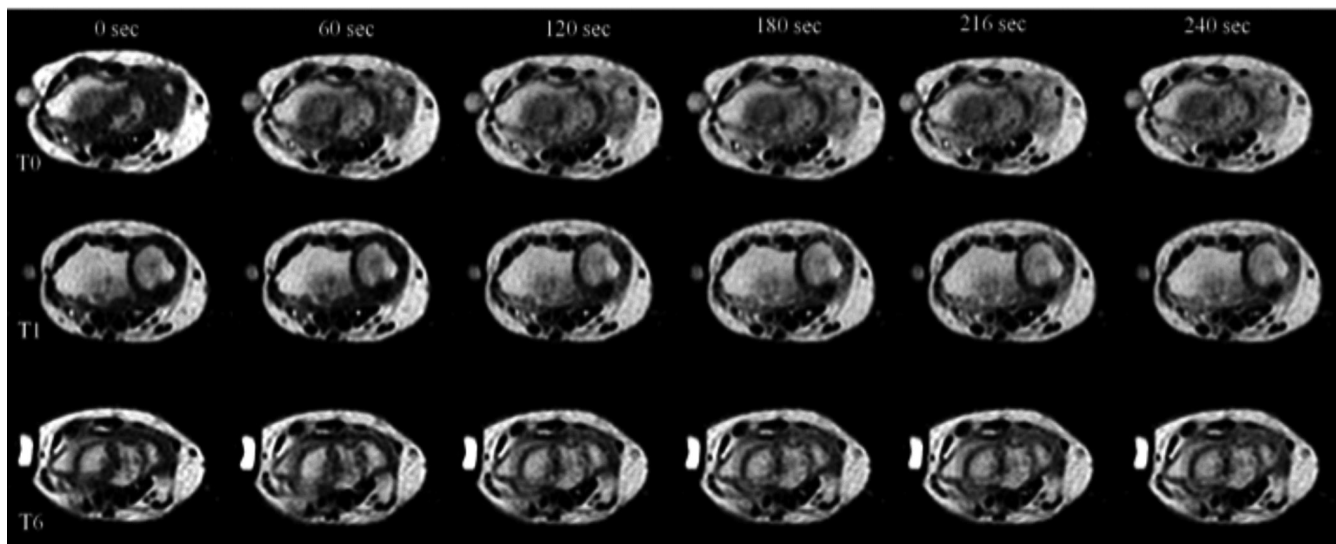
Representative dynamic contrast-enhanced MRI of the wrist in a patient with rheumatoid arthritis. Sequences in the left column show the pre-contrast images, followed by those acquired after 60, 120, 180, 216 and 240 s, respectively. The first row corresponds to baseline examination (t0), the second to the examination performed after one month of treatment (t1), and the third to the 6-month examination (t6). In the represented patient, RE decreased from 136.8 (t0) to 83.4 (t1) and 52.3 (t6). The sequences are spin echo (TR/TE: 100/16 ms; matrix: 160x128; FOV: 150x150).
